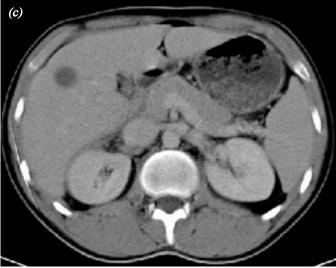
Abdominal CT scans showing (a) right renal explosion with intravenous contrast media extravasation; (b) right lobe hepatic hematoma; (c) remanescent post-traumatic cystic hepatic lesion.
